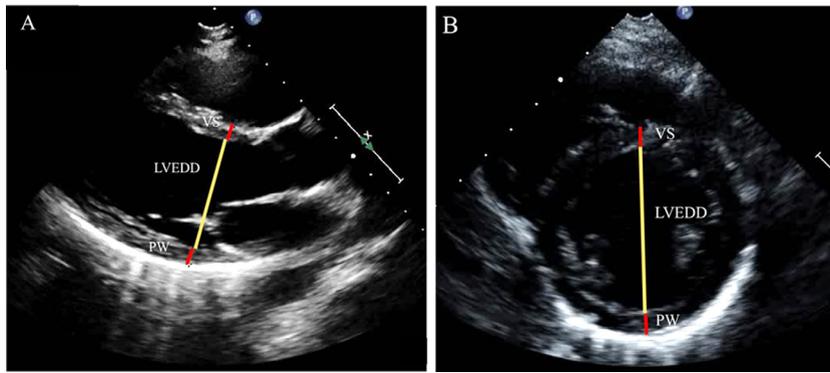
Linear measurements for LV mass calculation via parasternal long axis (A) and parasternal short axis (B). VS=interventricular septum; LVEDD=left ventricular end-diastolic dimension; PW=posterior wall.
